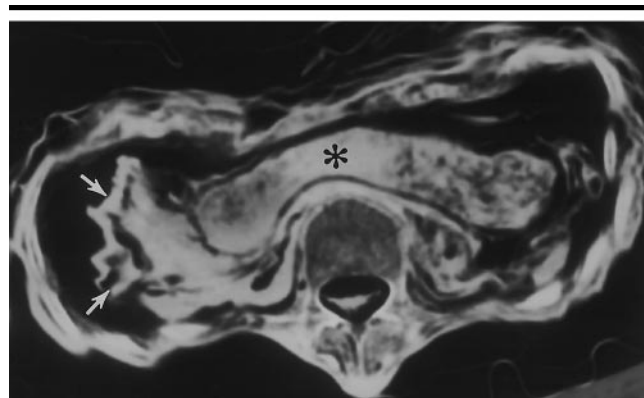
Transverse CT section through the upper abdomen (obtained on September 25, 1991) shows dehydration and severe shrinkage of the liver (arrows) and other organs. Only the transverse colon (*) has a reasonably normal shape. Stool from a prior meal(s) is present.
